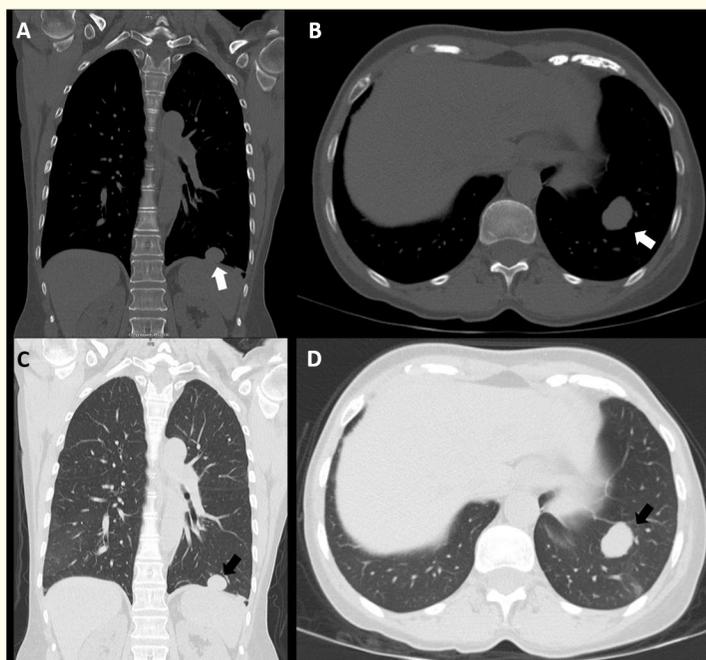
Computerized tomogram (CT) of the Chest in mediastinal (A and B) and lung windows (C and D). There is a well circumscribed solid mass in the left lower lobe (white and black arrows) closely abutting the diaphragm without any evidence of mediastinal adenopathy.
